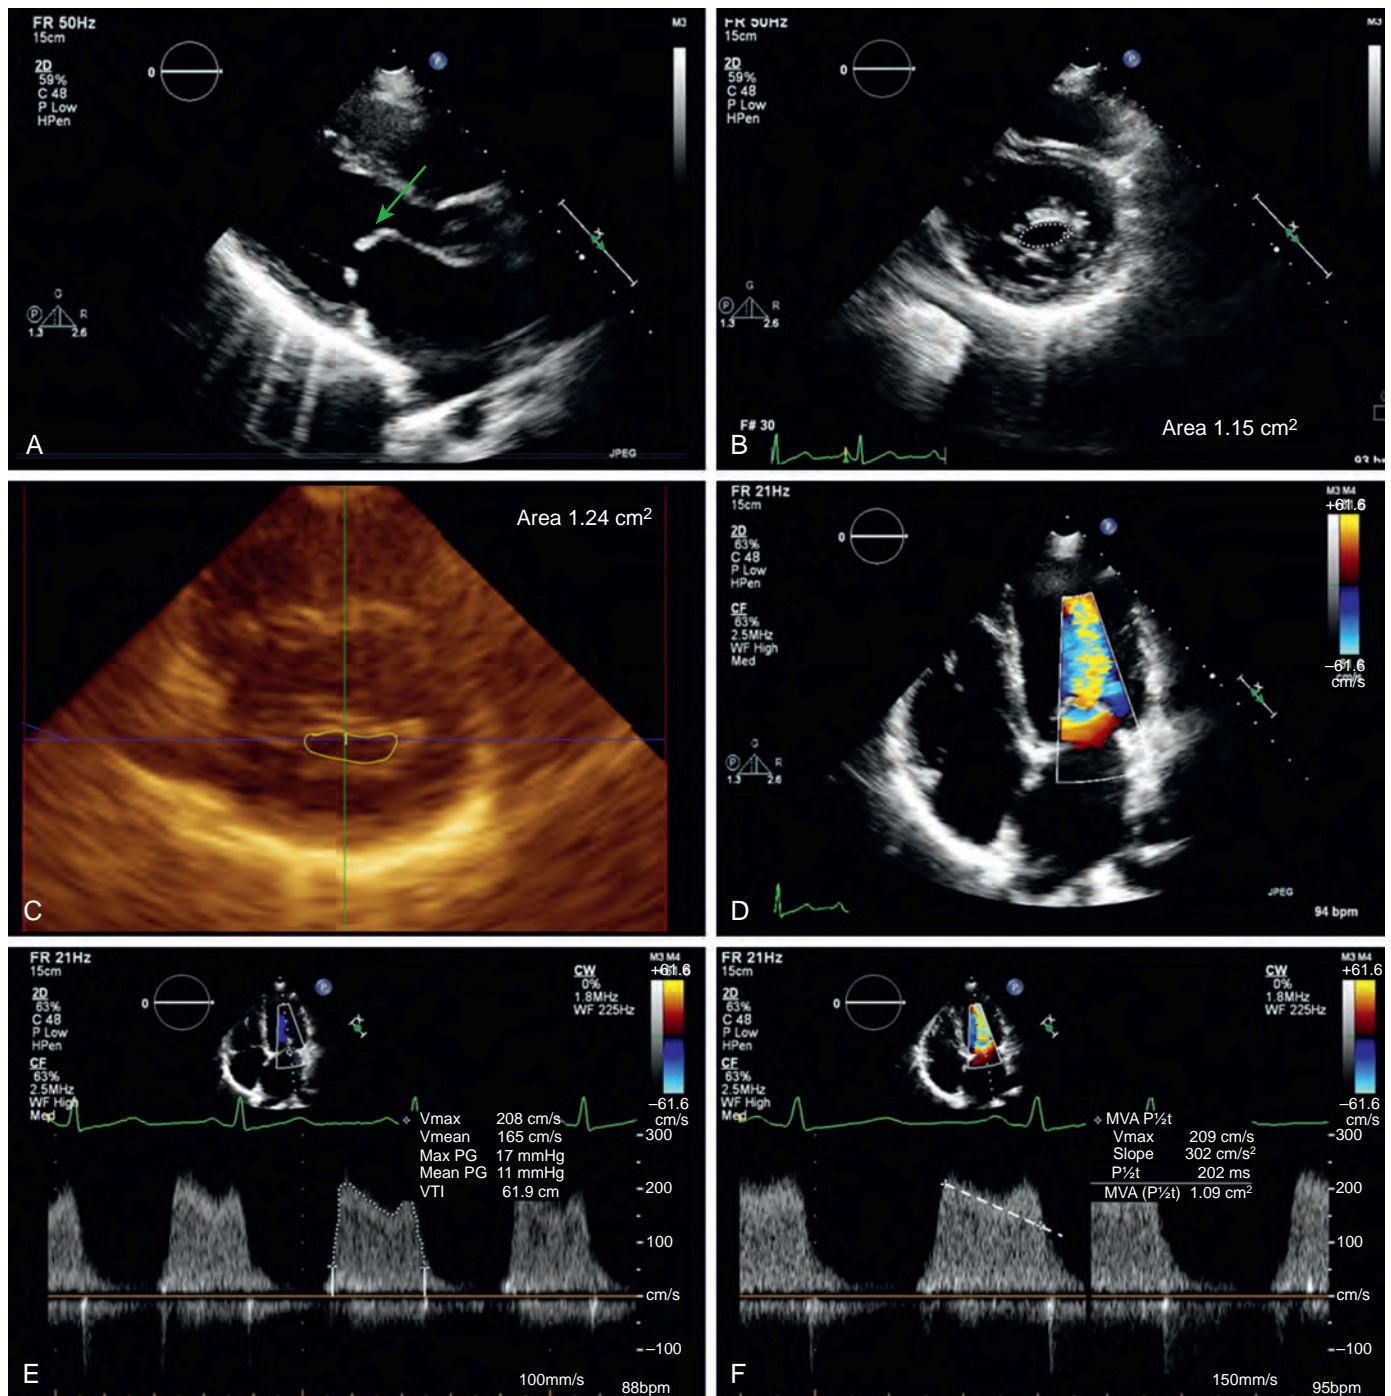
Typical echocardiographic findings in a patient with rheumatic mitral stenosis. A, Parasternal long-axis view demonstrates restricted mitral leaflet opening with doming of anterior mitral leaflet (arrow). Estimation of mitral valve area by planimetry from the parasternal short-axis view using two-dimensional (B) and three-dimensional (C) echocardiography is shown. D, Apical four-chamber view with color Doppler shows turbulent forward blood flow jet through the narrowed mitral orifice. Continuous wave Doppler is shown for estimation of transmitral gradients (E) and mitral valve area (F) by the pressure half-time method.
